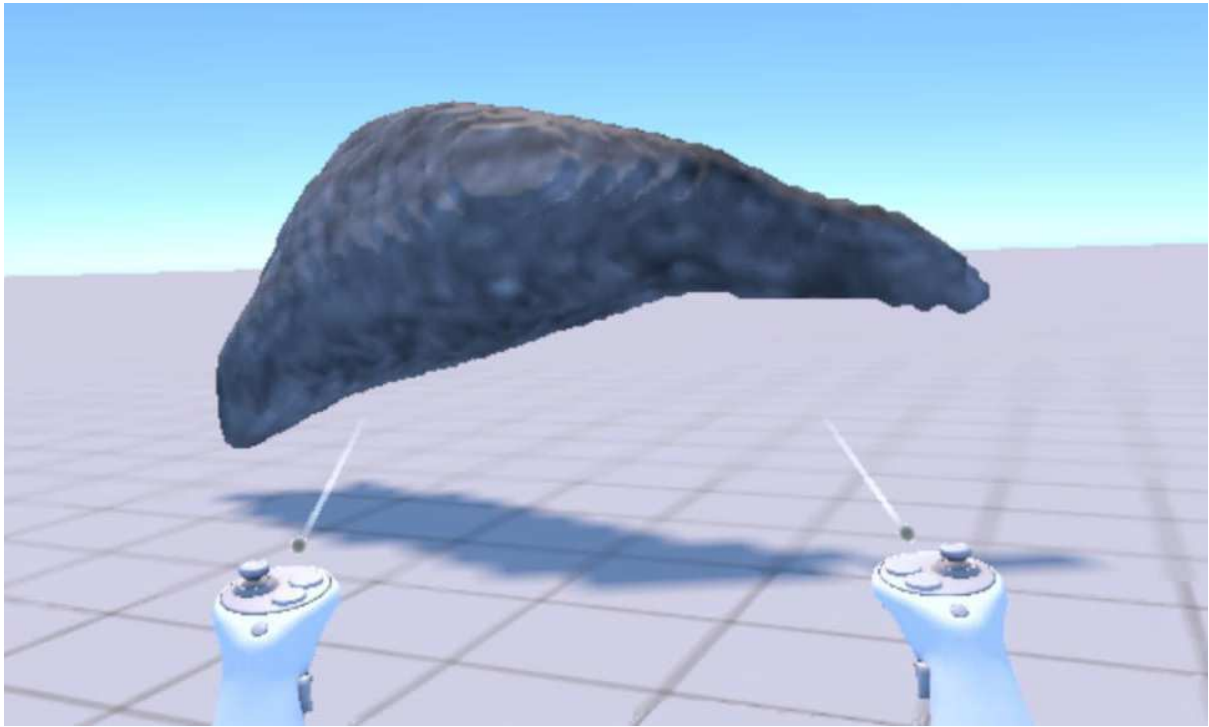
External view of the uterus surface mesh: texture-mapped ultrasound intensities.
